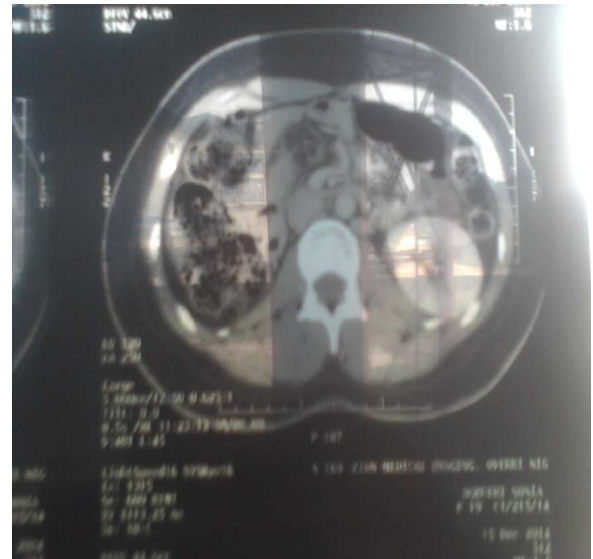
CT scan of the patient's abdomen
